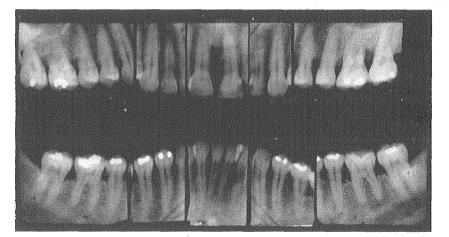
Roentgenograms taken before treatment of the case shown in Figure 426.
